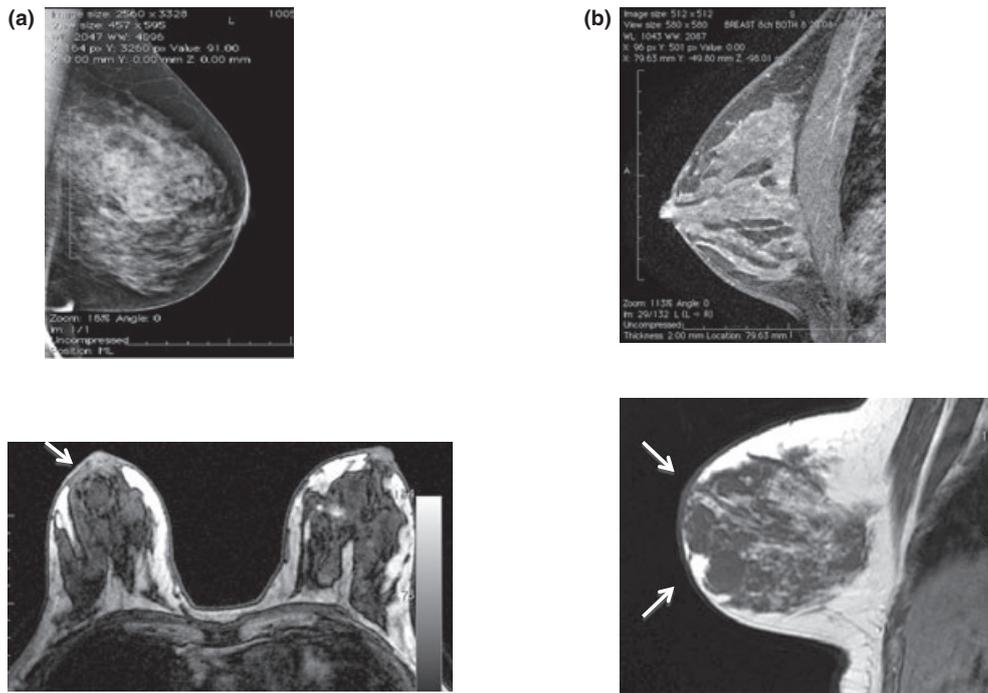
(a) MRI demonstrating close proximity of breast to the NAC (b) MRI demonstrating the crucial angle at which the plane deepens as the breast moves away from the NAC.
